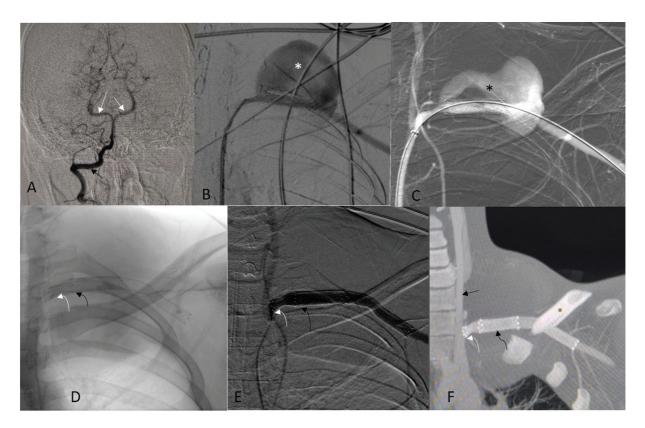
(A) Right vertebral artery (*black arrow*) angiogram shows opacification of the bilateral posterior cerebral artery (*white arrows*) and nonvisualization of the right anterior spinal artery. (B,C) Digital subtraction angiography (DSA) run shows the large pseudoaneurysm (*) and placement of the longer covered stent, just distal to the left vertebral artery origin. (D) X-ray, (E) DSA run, and (F) computed tomography (CT) angiography images after placement of a longer stent (*white curved arrows*) through the initial stent (*black curved arrows*) show complete obliteration of the recurrent pseudoaneurysm and preservation of the left vertebral artery (*black arrow*).
